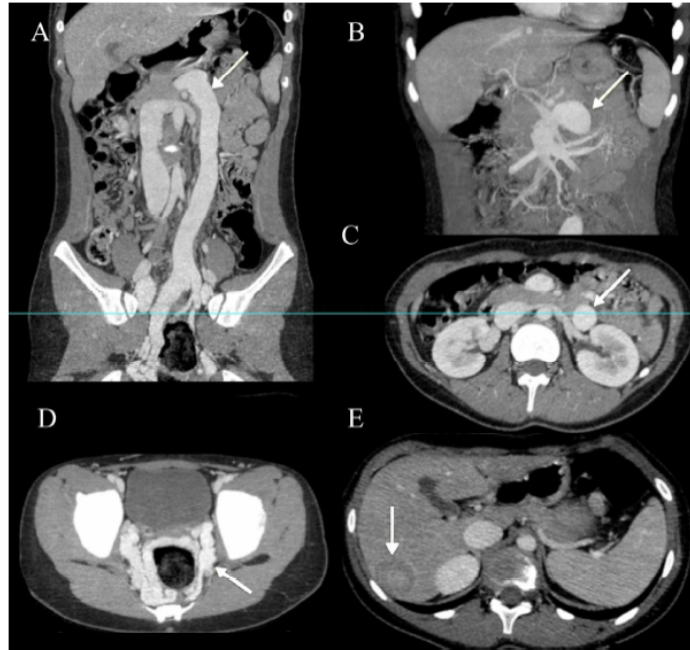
Contrast Enhanced Angio-Computed Tomography (CT) scan. A) Multi Planar Reformatted (MPR) Coronal view: extra-hepatic shunt (arrow) taking its origin from Superior Mesenteric Vein (SMV) and ectatic Inferior Vena Cava (IVC). B) Maximum Intensity Projection (MIP) Coronal view: confluence (arrow) of the extra-hepatic shunt with SMV. C), D) Axial views following the course (arrows) of the shunt in the abdomen and in the pelvis. E) Axial view: Nodular Regenerative Hyperplasia of the right lobe (arrow).
